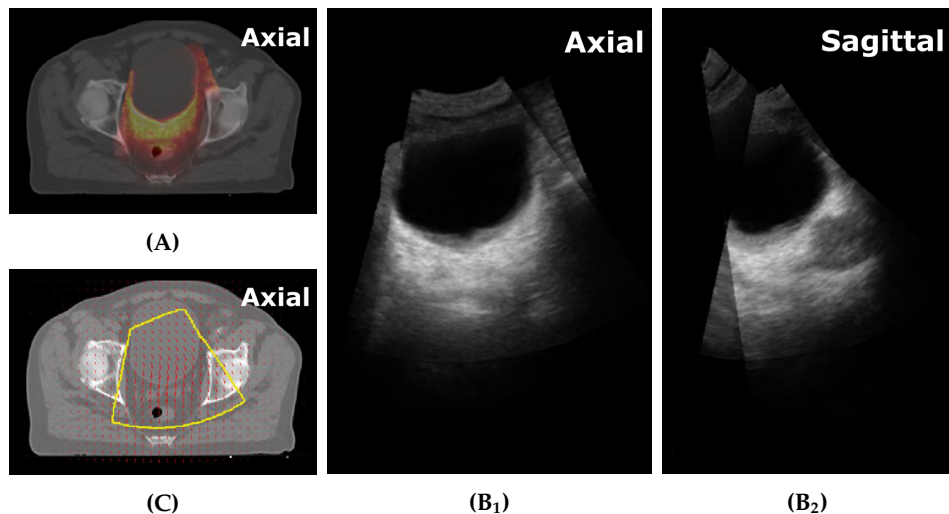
Example of overlap between CT (grey) and US (color) (A), and between two US images (B) of Patient 1. US based DIR can only be performed on the area where both CT and US information (of both US_{sim} and US_{tx}) is available. In this example only the prostate and its surrounding tissue, e.g. a part of the bladder, are present in both US images. In panel (C) only the overlapping area of both US images (yellow contour) contains information where the deformation field (2D representation with red arrows) is based on. The field propagates further beyond this border.
